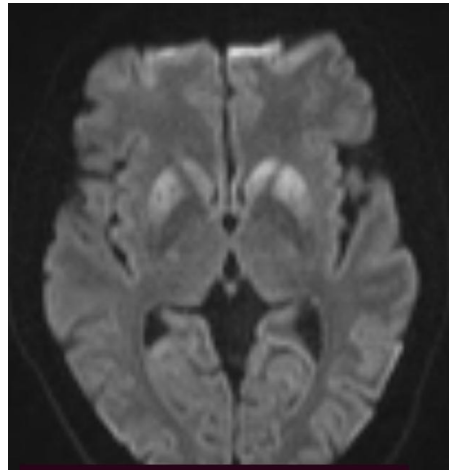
Diffusion Weighted Imaging (DWI) Sequence of Bilateral Corpus Striatum
